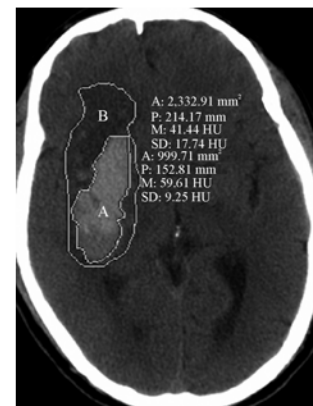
CT scan showing region of interest for ICH and PHE
